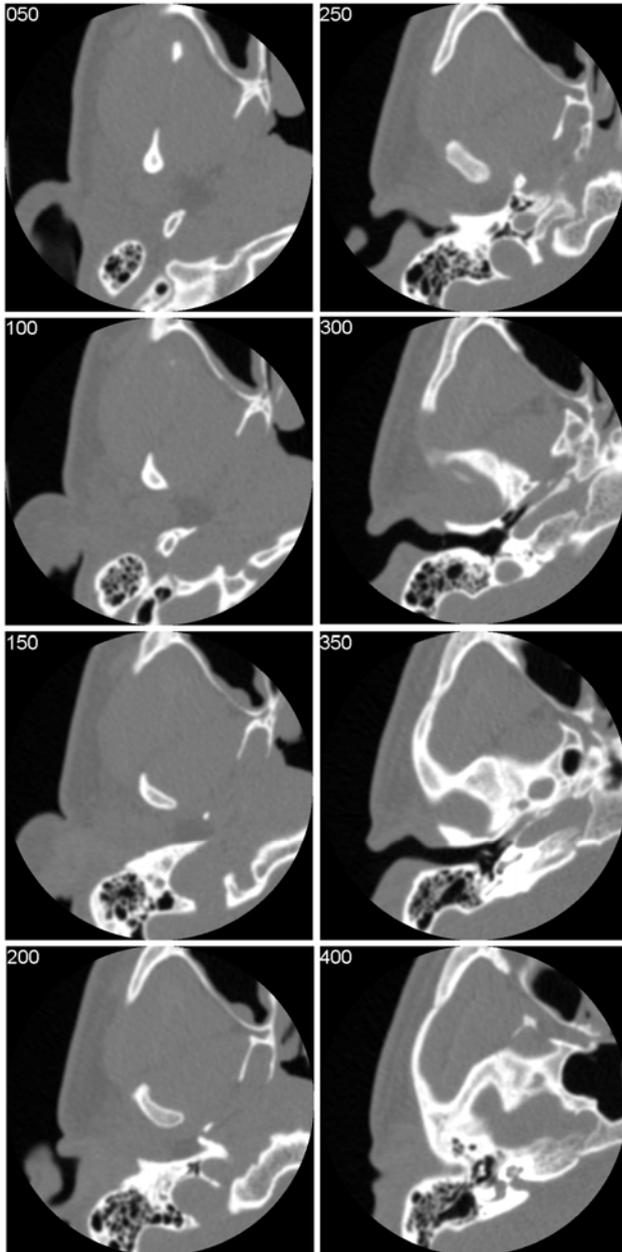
Two-dimensional images of left temporomandibular joint achieved by survey computed tomography scanning.
